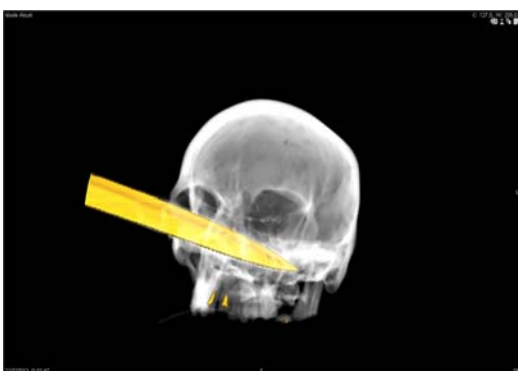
Cranial and orbital volumetric CT scans—a three-dimensional reformatting image.
